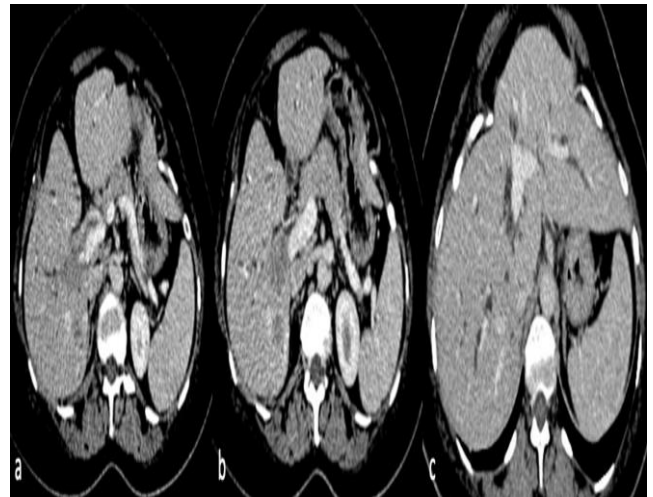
(A-C): Axial section of Contrast enhanced CT of the abdomen in the portal venous phase shows an ill-defined, poorly enhancing mass at the porta hepatis seen to encase hepatic artery with complete occlusion of the right branch of the portal vein and causing upstream bilobar intrahepatic biliary radical dilatation.
